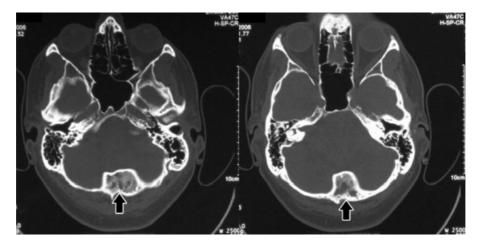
Brain computed tomography scan ("bone windows") demonstrating an expansile, ground glass appearing lesion (arrows) of the occipital bone. Note the preserved and thickened inner and outer bone cortex.
